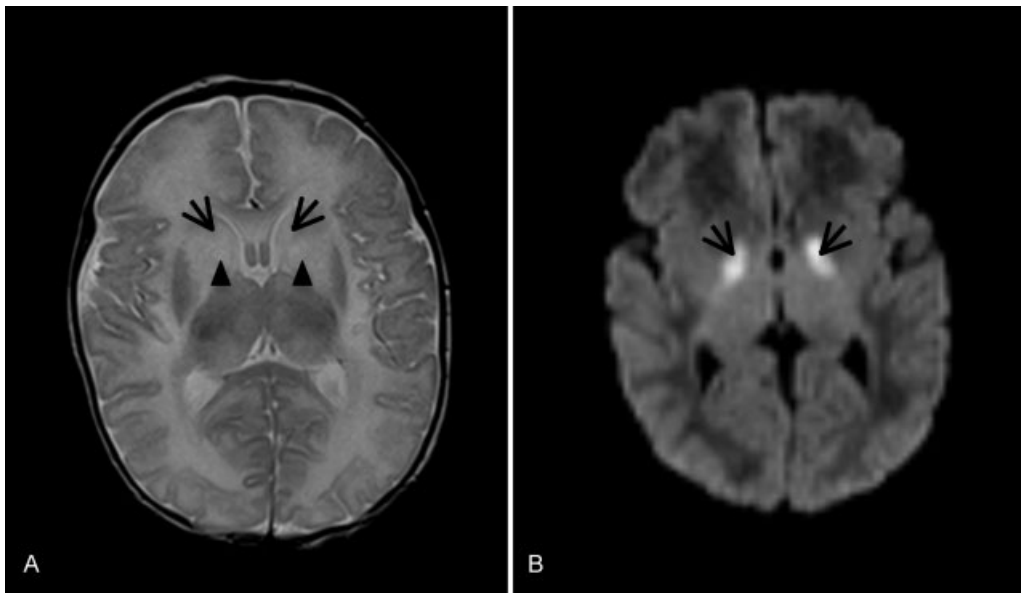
Axial T2-weighted and diffusion MRI images of the brain performed 12 days after birth depicting Leigh-like changes, with (A) bilateral increased signal change in the caudate nucleus (black arrow), globus pallidus, and medial putamen (arrowhead) and with (B) pallidal lesions with restricted diffusion (arrows). MRI, magnetic resonance imaging.
